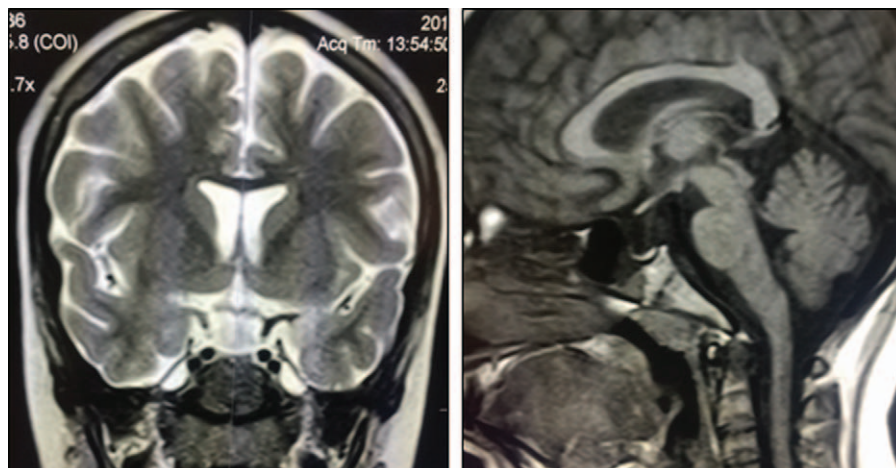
MRI brain demonstrates the sella filled with Cerebrospinal fluid and the infundibulum can be seen to traverse the space which is consistent with empty sella. CSF=cerebrospinal fluid, MRI=magnetic resonance imaging.
